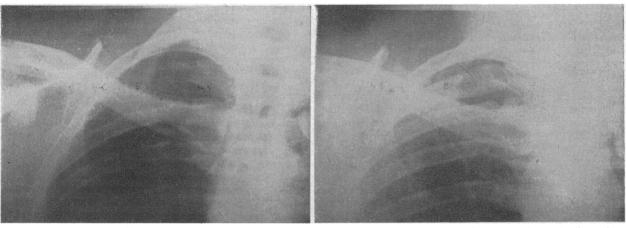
Case 2. Recalcification of Hodgkin's deposits in the third rib after treatment with cyclophosphamide. Radiographs taken on January 1 and July 30, 1960.
